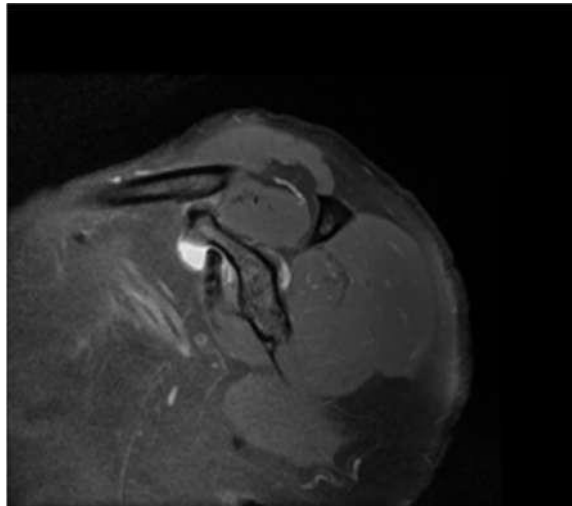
MRI image of Joint effusion
